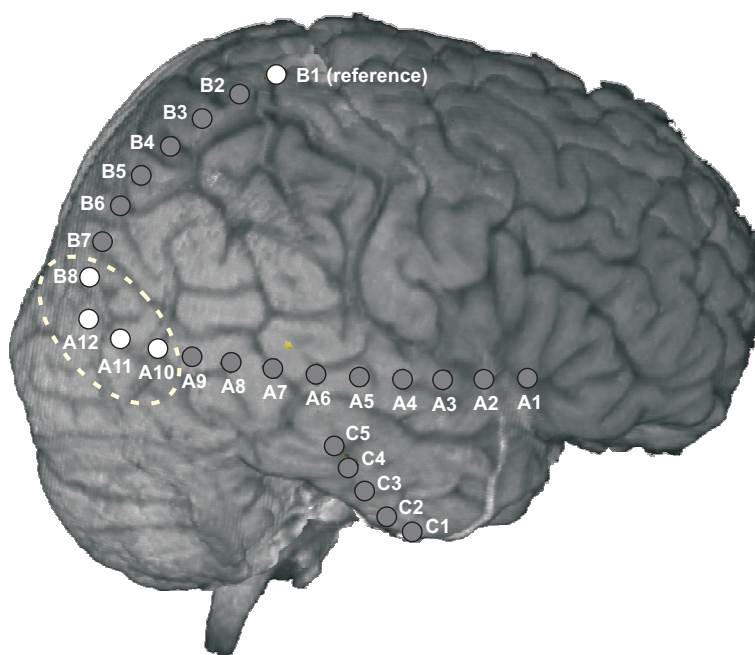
MRI scan with electrode positions. The electrodes of the seizure onset zone indicated by the proposed methodology are marked.
